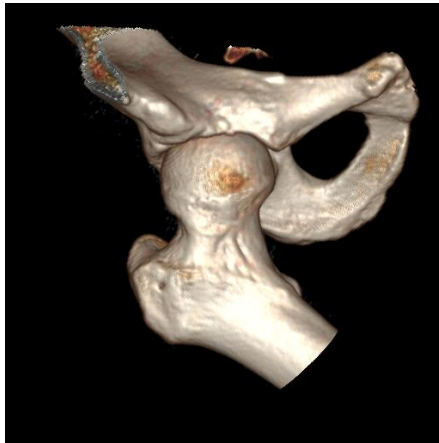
3D CT image of the hemi-pelvis
